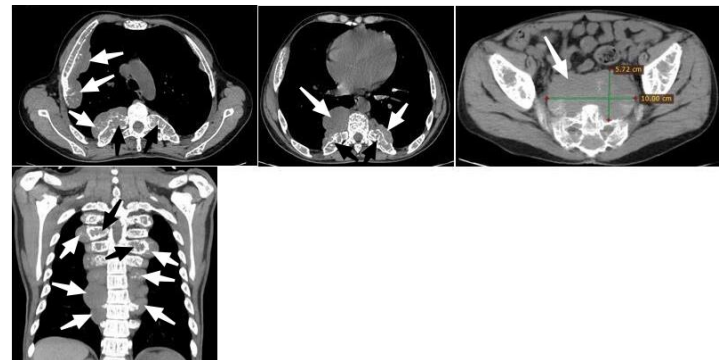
CT demonstrated well-circumscribed and smoothly-outlined lobulated soft tissue masses (white arrows) bilaterally in the paracostal region, paraspinal regions of the chest and presacral spine. Generalised rib expansions (black arrows) in keeping with hyperplasia of the bone medulla were noted.
